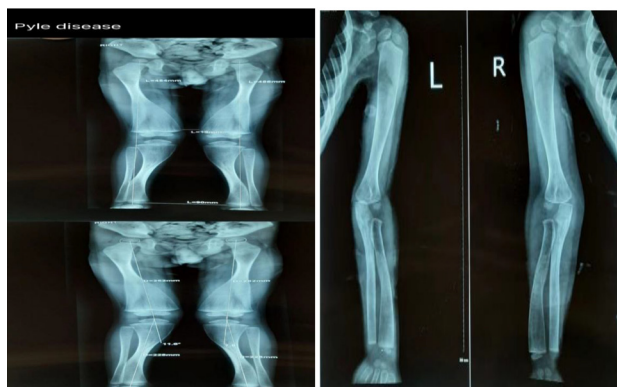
Radiographic results of the upper and lower extremities.
